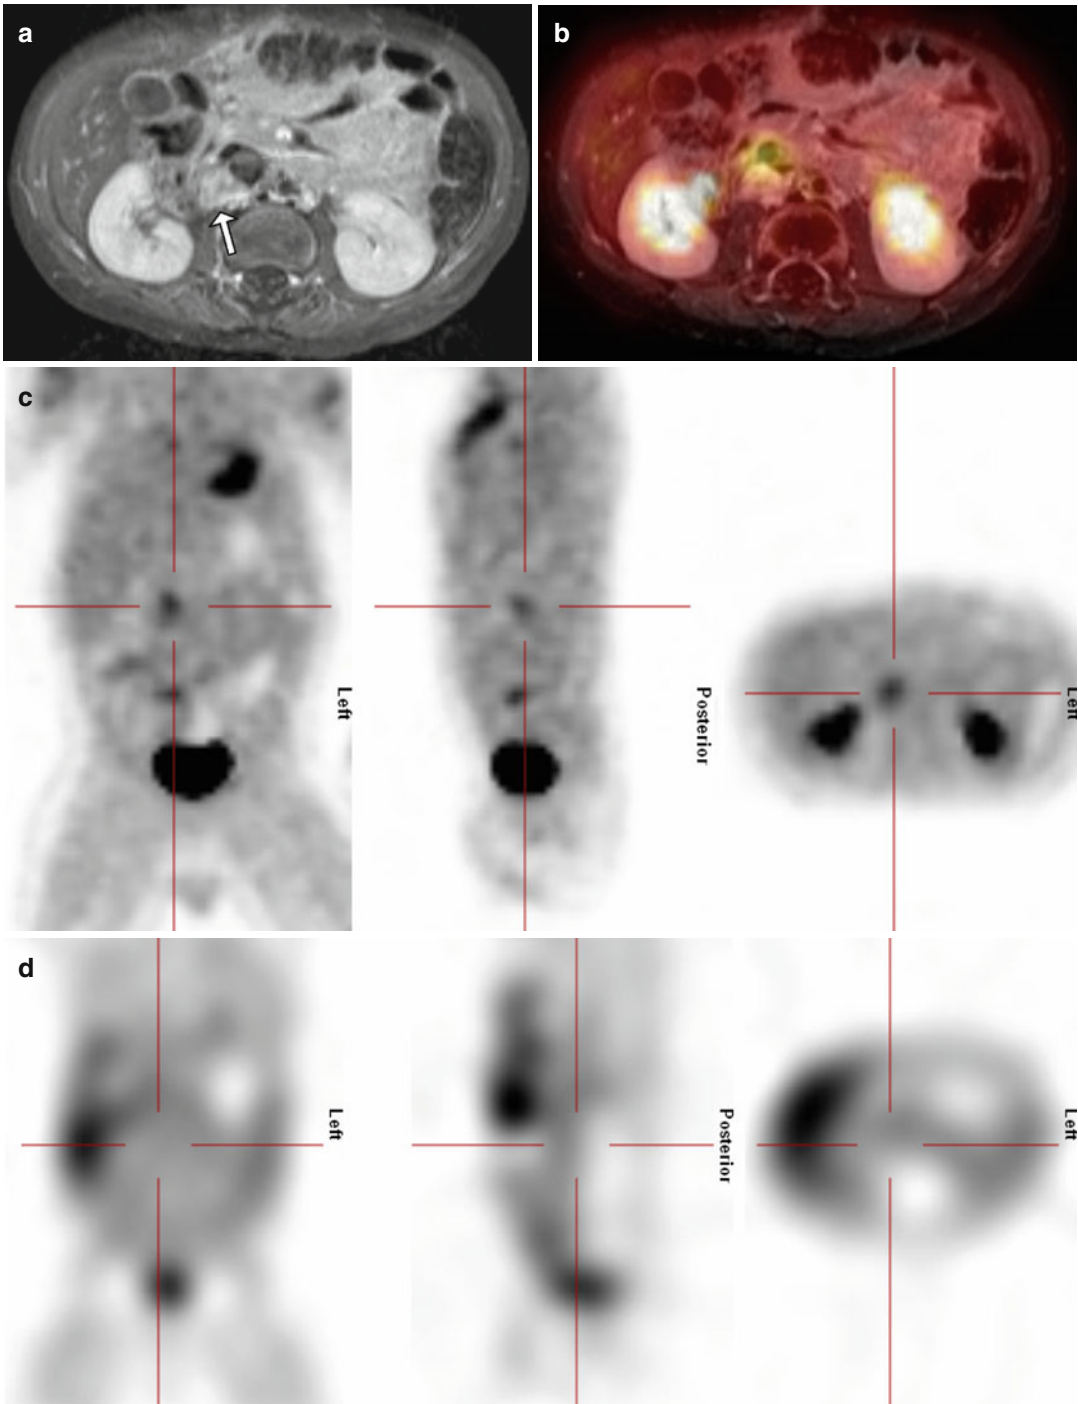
A 9-month-old girl with stage IV neuroblastoma after chemotherapy. T1-weighted MRI shows a contrast-enhancing right-sided prevertebral lesion (*arrow*) (a). Fused MRI/PET (b) and PET (c) images demonstrate
